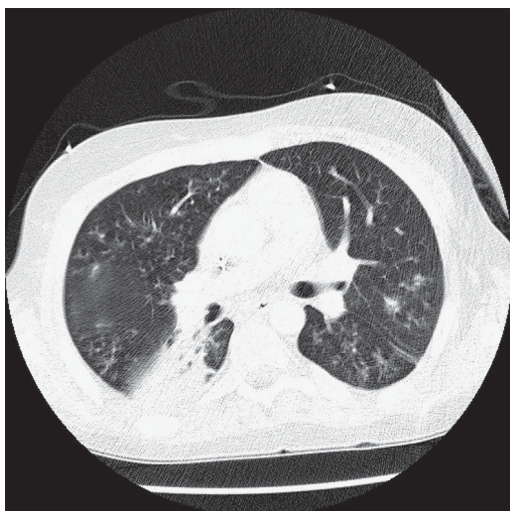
Follow-up CT scan one week later.
